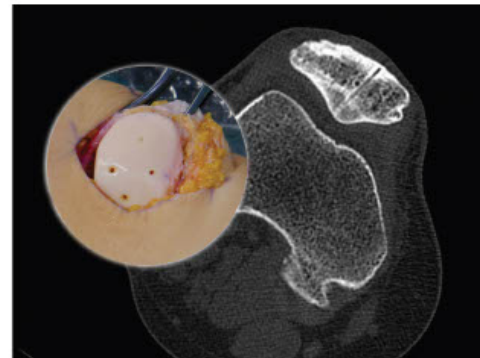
A computed tomography scan taken 6 months after surgery and a surgical image of a patellar fresh osteochondral allograft obtaining a low assessment computed tomography osteochondral allograft score (1 point—superior graft signal density relative to the host bone).
